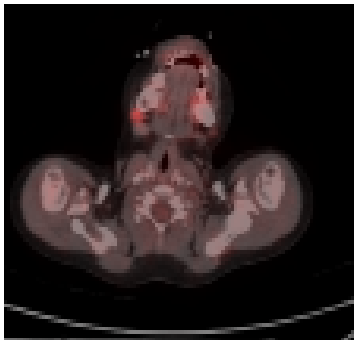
Post treatment PET CT whole body
